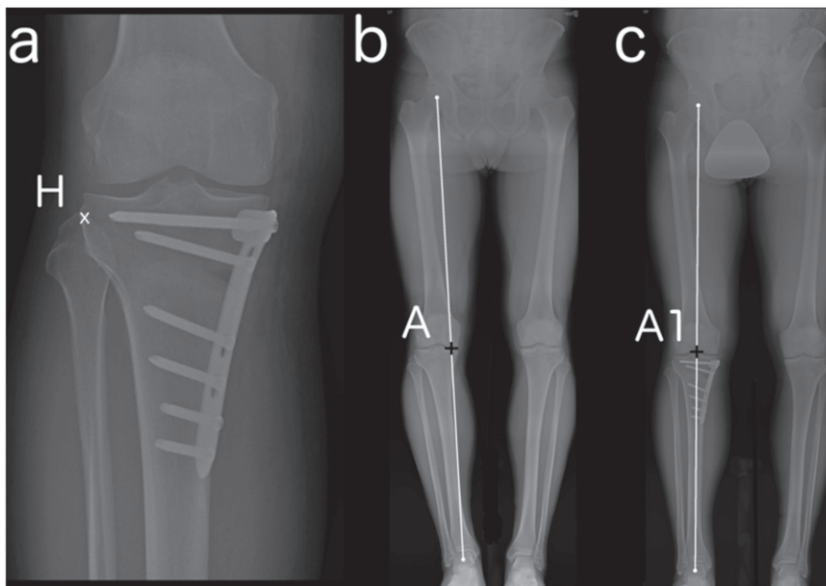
(a) Radiograph of a completed opening wedge HTO using a fixation plate. The osteotomy is made across the tibia and a wedge opened about the hinge point, H. (b, c) This moved the preoperative WBA at the joint line more laterally (as demonstrated by the change from point 'A' to 'A1').
